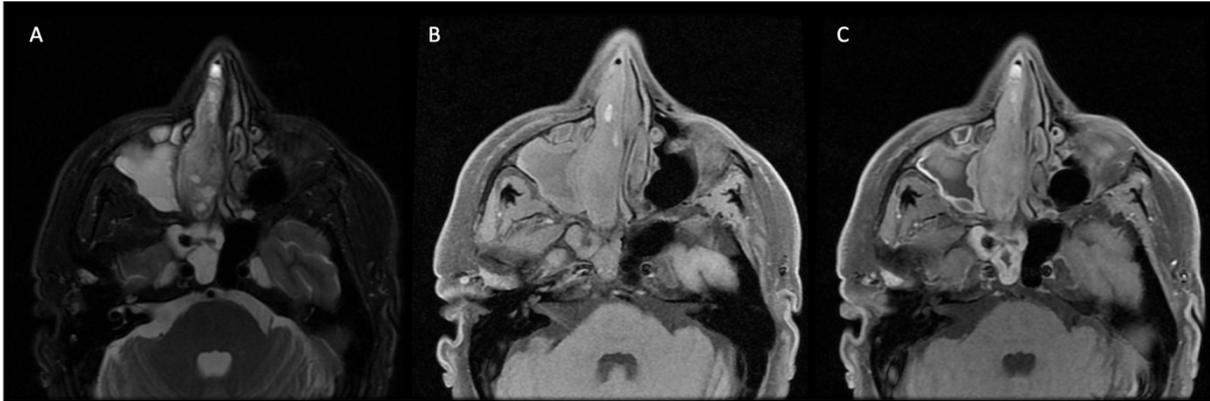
Fig. 4. MRI sinuses. (A) Axial T2 fat-suppressed, (B) axial T1, (C) axial T1 fat-suppressed post contrast images demonstrate a soft tissue mass hyperintense on T2, iso-/hyperintense on T1 and with faint non-homogenous enhancement post contrast.
